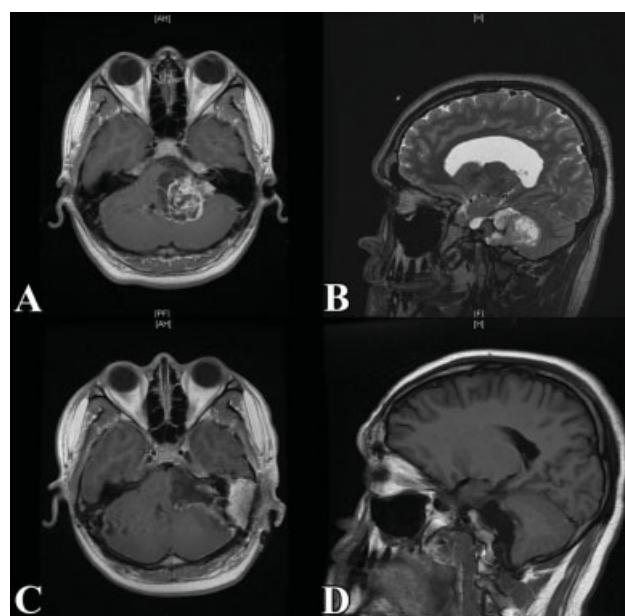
Case Report MRI. Preoperative axial T1 MRI (A) and sagittal T2 MRI (B). Postoperative axial T1 MRI (C) and sagittal T1 FLAIR MRI (D) for resection of large vagal schwannoma. Minimal postoperative clip artifact is demonstrated.
